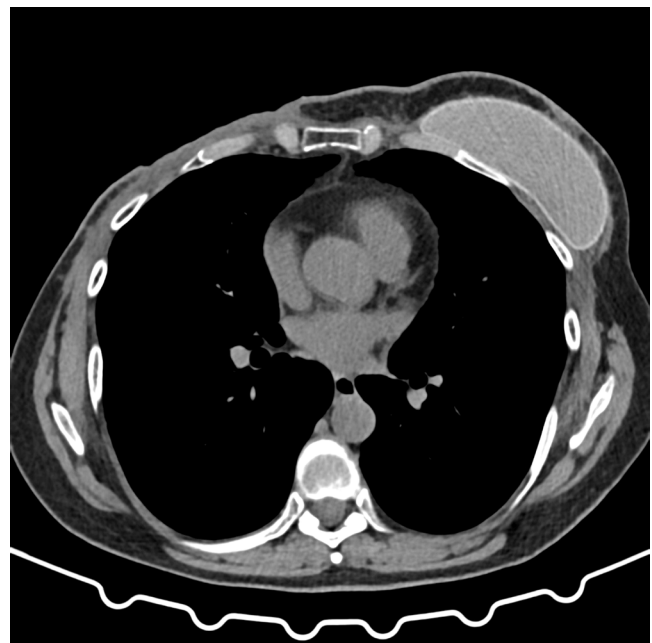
Computed tomography scan showing skin thickening and irregularity over the surgical scar.
